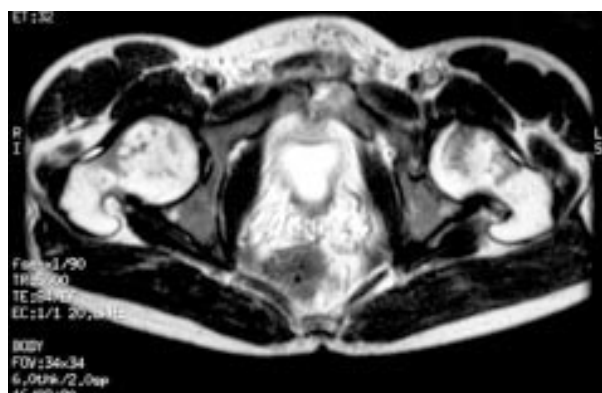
Magnetic resonance imaging scan (T2 images) with bilateral abnormal hyperintense signal, more on the left side of the symphysis pubis and normal anatomy and normal signals from the musculotendinous structures.
